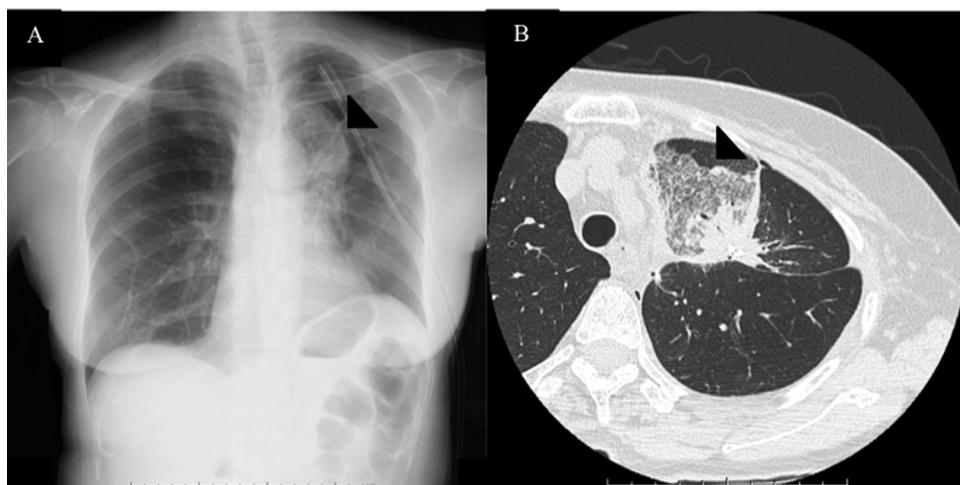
(A): Chest radiograph showing atelectasis and volume loss (arrowhead). (B): Computed tomography imaging demonstrating consolidation and atelectasis of the lingular segment (arrowhead).
